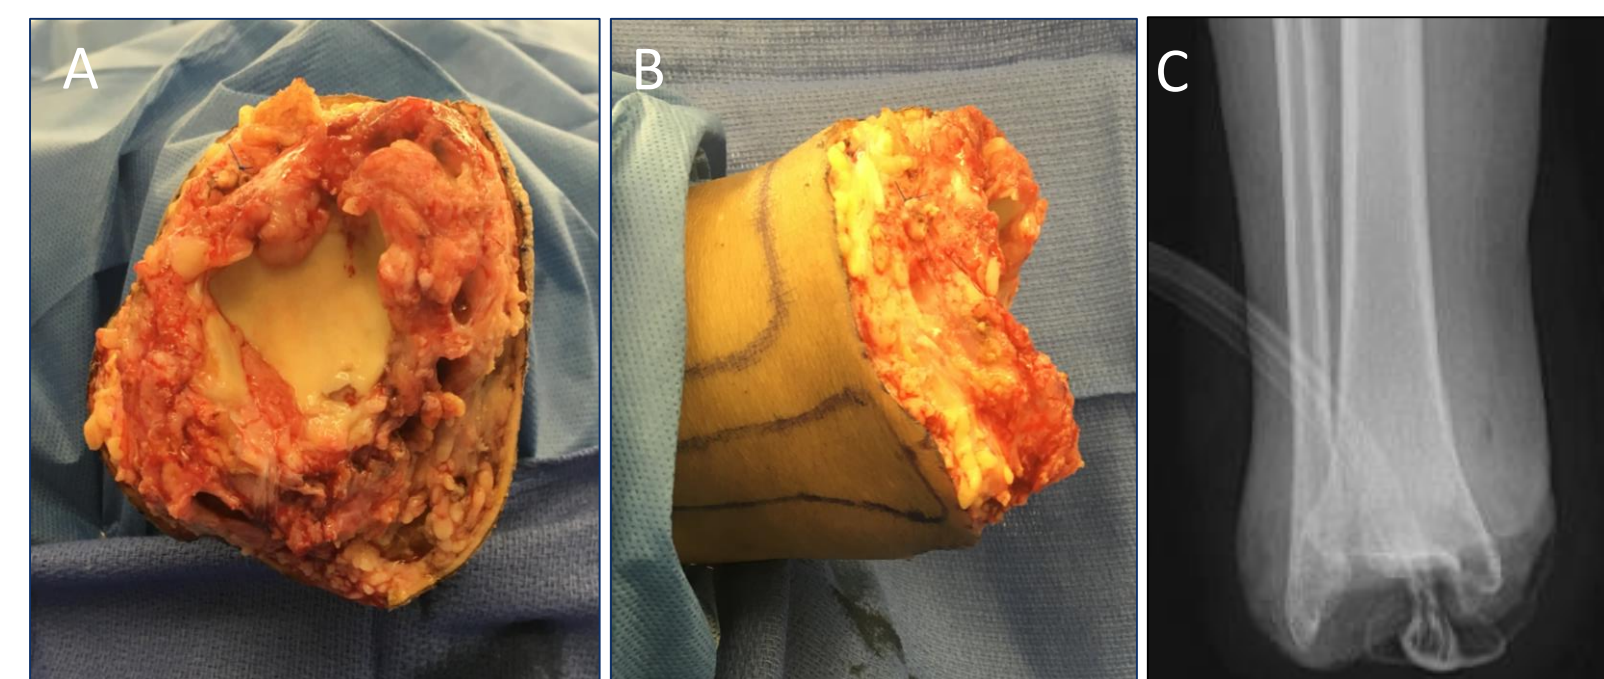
Exposed ankle cross-section prior to release of tourniquet and post-operative radiograph displaying use of NPWT with instillation.
